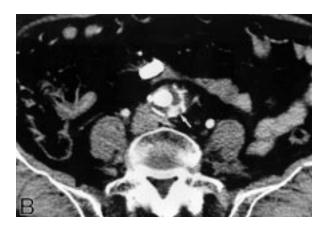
Postoperative spiral computed tomography in the same patient showing small amount of contrast accumulation in the sac secondary to collateral perfusion. The contrast was seen only on two axial 3-mm slices.
